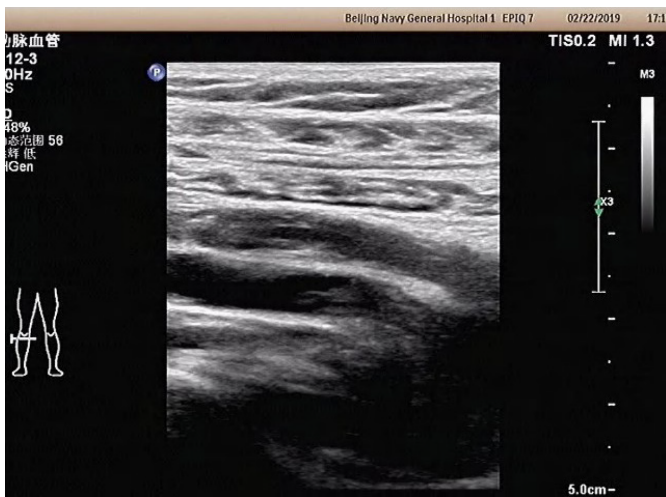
Doppler ultrasound revealed a deep venous thrombosis in the right popliteal vein.
